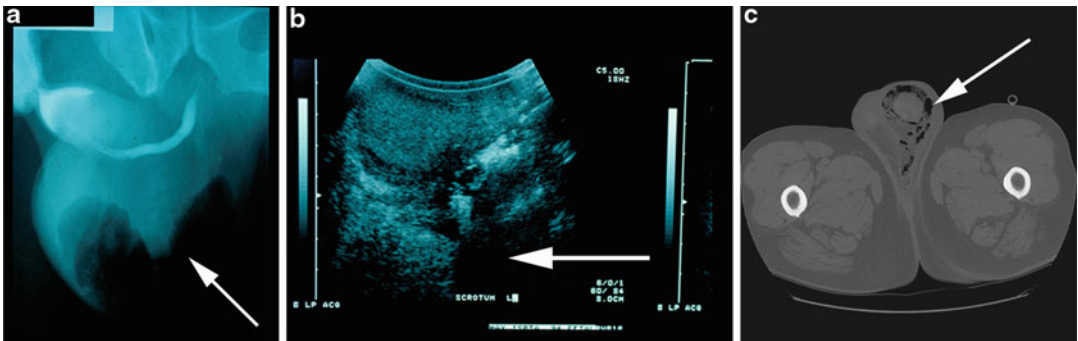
Radiographic appearance of subcutaneous or deep gas in the soft tissues. This should prompt immediate surgical debridement. (a) Retrograde urethrogram plain radiograph demonstrating gas within the scrotum (*arrow*).
